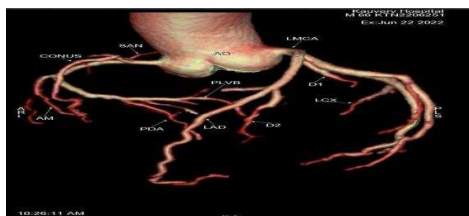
Normal Coronary artery anatomy. (3D CT coronary Angiogram)
